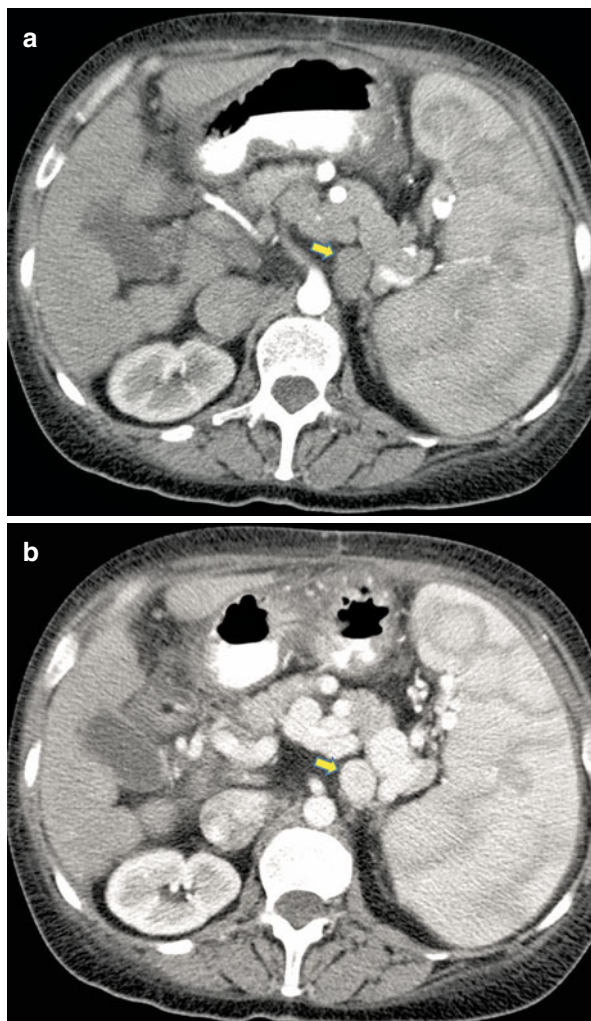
Axial noncontrast CT scan shows nonopacified collateral vessel (arrow) in lienorenal region that may mimic lymph nodes
